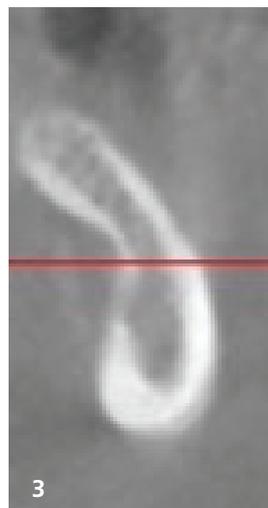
Initial clinical situation of the right side. The ridge was too narrow for implant placement. Fig. 2: Initial radiograph of the right side. Cross section at approximately the level where the first implants were to be placed behind the premolars. Fig. 3: Initial radiograph of the left side showing the medially converging ridge and substantial atrophy. Fig. 4: Intra-op view of the right side during augmentation. Umbrella screws *in situ*.
